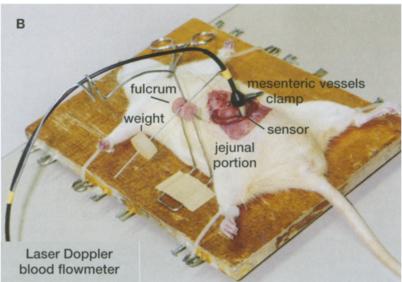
Sensor of laser Doppler flowmeter holding system in jejunal serosa. After the abdominal cavity had been opened through a midline incision, the jejunum was cut. The sensor holding system includes loose fixation of the system line and synchronization of the movements of the jejunum and the sensor, which was held by a fulcrum.
